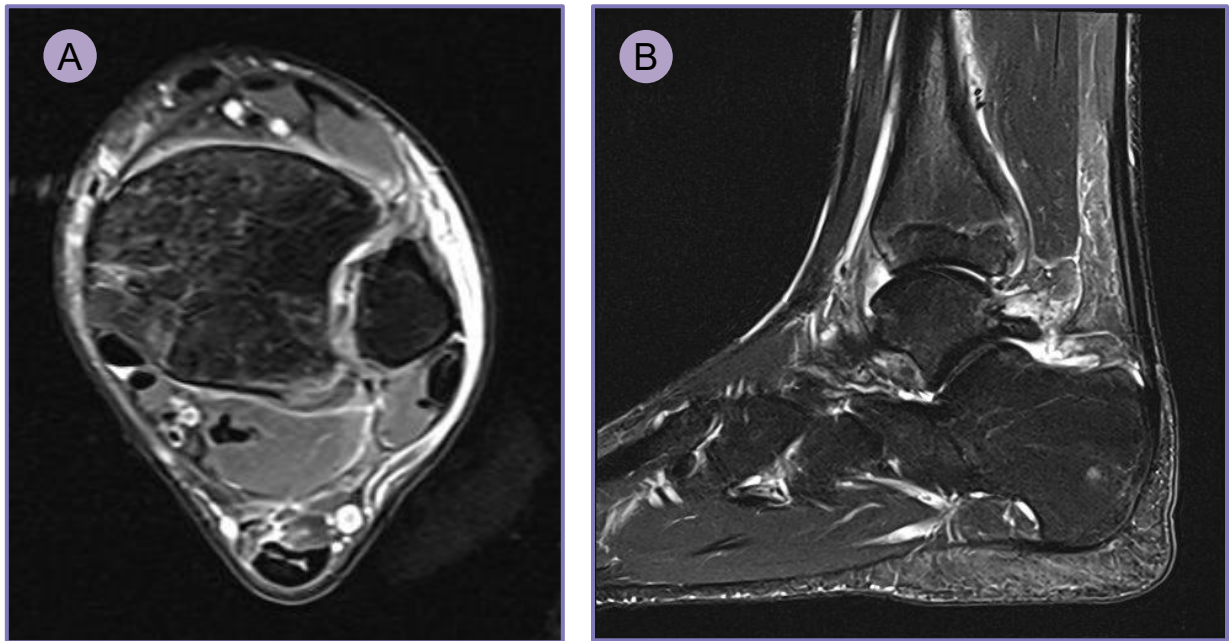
MRI demonstrating ligamentous injuries: (A) transverse and (B) sagittal.
